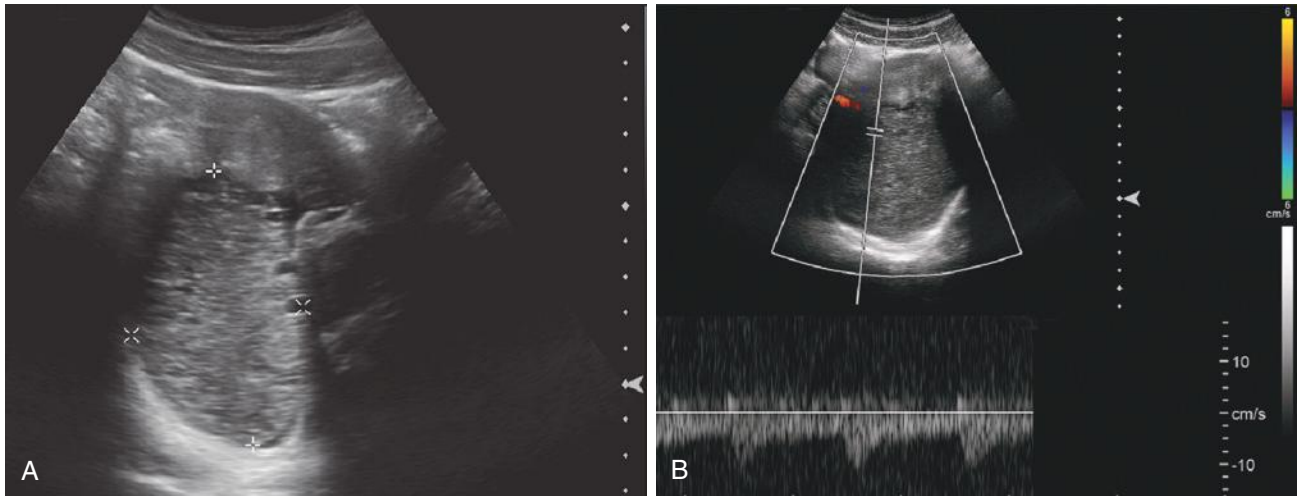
A 19-year-old woman presented with severe pelvic pain and negative pregnancy test. She had been in an emergency room 1 month earlier with the same symptoms. A, A pelvic sonogram demonstrates an enlarged ovary with peripheral small cysts. B, Doppler sonogram of the ovary demonstrates arterial and venous blood flow. Three hours later an avascular necrotic ovary from ovarian torsion was removed at surgery. Don't be falsely reassured by an apparently normal Doppler sonogram when ovarian torsion is suspected.
